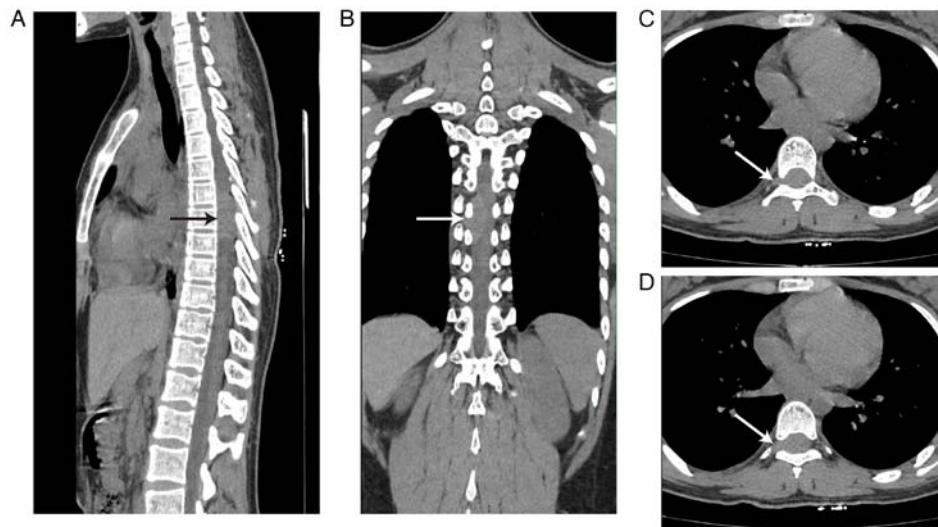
Non-contrast CT images of a mass in the T6-8 plane (arrows). (A) Median sagittal section demonstrated aggressive and invasive growth and indistinct borders from surrounding tissues. (B) Coronal section demonstrated that the spinal cord was significantly compressed and displaced to the left side. (C) Transverse sections demonstrated that the tumor grew out of the spinal canal through the intervertebral foramen. (D) Transverse sections demonstrated that the tumor grew out of the spinal canal through the intervertebral foramen significantly.
